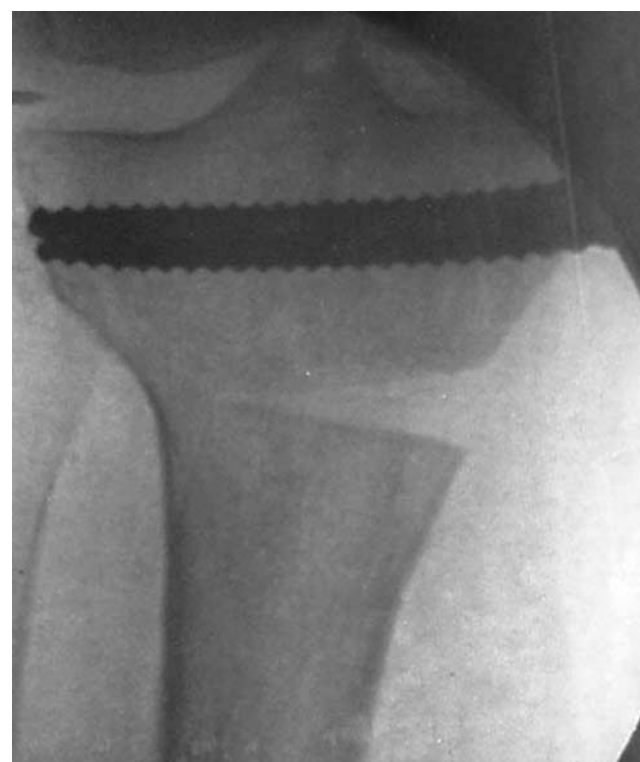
Intraoperative radiograph demonstrating opening of the osteotomy before closure.
